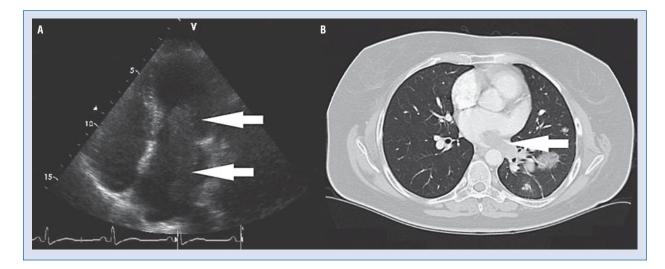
Left atrial leiomyosarcoma was a soft, friable, 2-segmented mass in the left atrium measuring 5×2.1 cm, but was stretched into 8.1×3.1 cm while protruding into the left ventricle during diastole on echocardiography (A); and a hypoattenuated signal in the left atrium, and extended into the left lung (arrow) on axial computed tomography (B).
